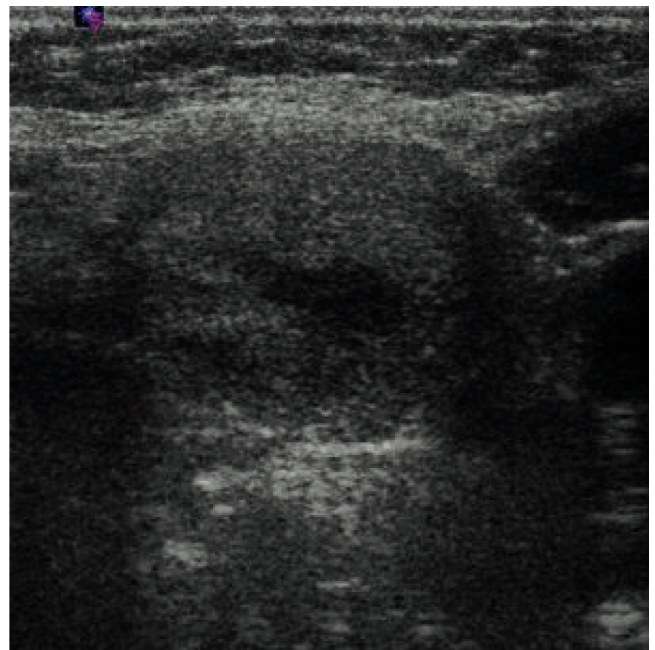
Case 1: Transverse gray-scale ultrasonogram of the neck: submandibular mass. The mass appears as a submandibular solid lesion with heterogeneous internal structure at the left anterior cervical triangle.
